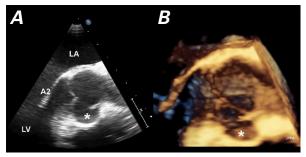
Transesophageal echocardiograms. A) This 2-dimensional midesophageal long-axis view shows a large pseudoaneurysm (asterisk) arising from between the left and right coronary sinuses of Valsalva. B) This 3-dimensional view shows the pseudoaneurysm (asterisk) and its narrowed neck communicating with the aorta
